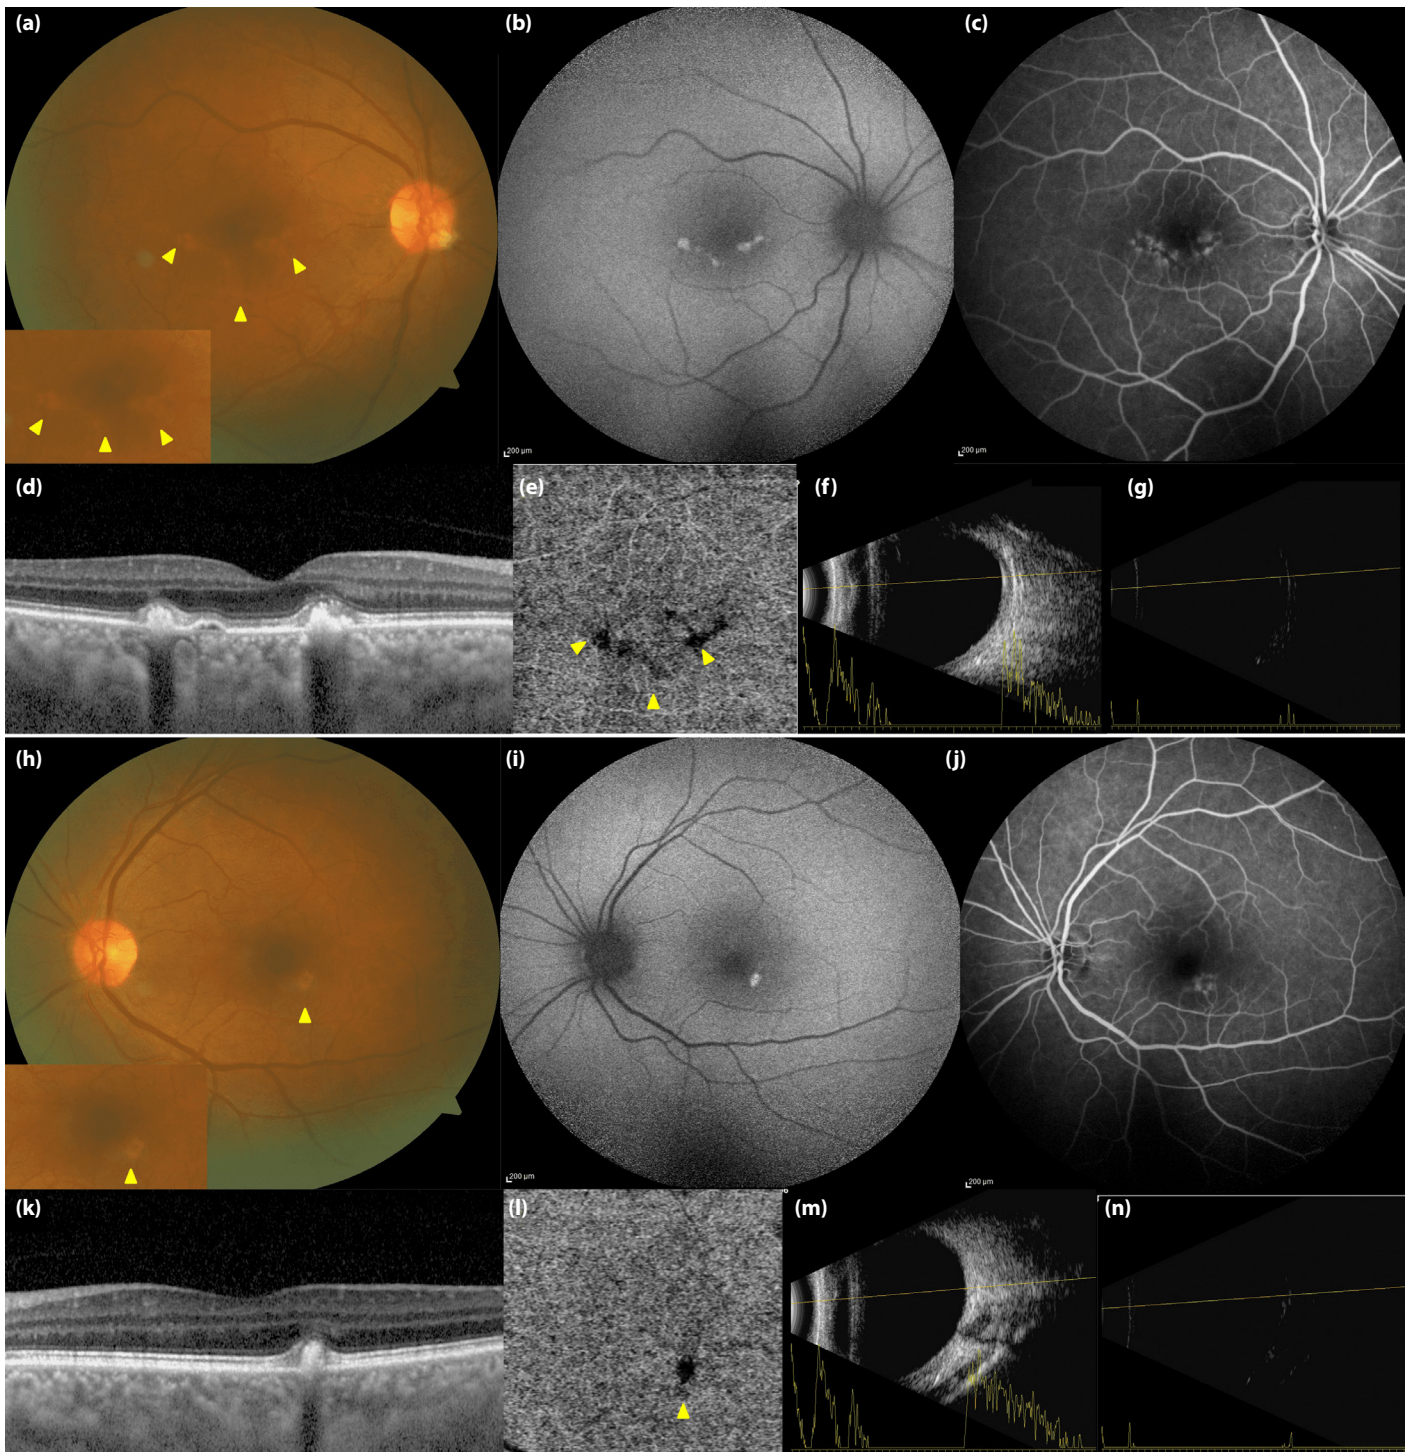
Right eye; color fundus picture, multiple, pale, yellow-white, and round-shaped lesions with ill-defined borders at the inferior part of the fovea (yellow arrows) (a). Fundus autofluorescence (FAF) image and hyperautofluorescent foci at the inferior part of the fovea (b). Fundus fluorescein angiography, arteriovenous phase, and hyperfluorescence at the lesion site of the fovea (c). Optical coherence tomographic (OCT) picture, Subretinal drusen-like hyperreflective deposits corresponding to the lesion sites (yellow arrows) (d). Choriocapillaris slab (6×6 mm) of optical coherence tomography angiography (OCTA) and flow deficit areas (yellow arrows) corresponding to the lesion sites at the inferior part of fovea (e). B-scan ultrasonographic picture (10MHz probe) and multiple hyperechoic linear areas at the level of choroid and sclera with a gain of 100 dB and 50 dB. (f and g). Left eye; color fundus picture, a pale, yellowish, nummular lesion (yellow arrow) at the inferotemporal part of fovea (h). FAF image, hyperautofluorescence of the lesion (i). Fundus fluorescein angiography, arteriovenous phase, and hyperfluorescence at the lesion site of the fovea (j). OCT picture and subretinal hyperreflective deposit at the level of retinal pigment epithelium layer (yellow arrow) (k). Choriocapillaris slab (6×6 mm) of OCTA and flow deficit areas (yellow arrow) corresponding to the lesion site (l). B-scan ultrasonographic picture (10 MHz probe) and Multiple hyperechoic linear areas at the level of choroid and sclera with a gain of 100 dB and 50 dB (m and n).
